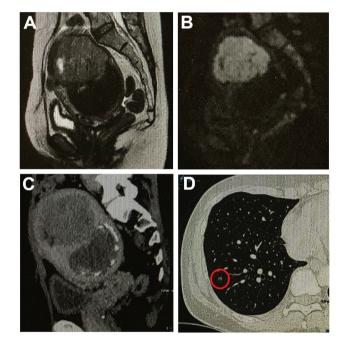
MRI imaging reveals a new tumor adjacent to the previously diagnosed myoma uteri. (A) MRI T1 and T2 imaging shows a marked low signal at T2W1 and an iso-signal at T1W1 on the caudal side of the tumor. (B) On the cranial side of the tumor, T2W1 shows mild hyperintensity and marked diffusion limitation. (C) Enhanced CT imaging reveals two tumors touching the top and bottom and occupying the left wall of the uterus. The caudal tumor appears associated with marginal calcification. (D) Enhanced CT imaging reveals a nodule suspected to be inflammatory in the lower lobe of the right lung, located inside the red circle.
